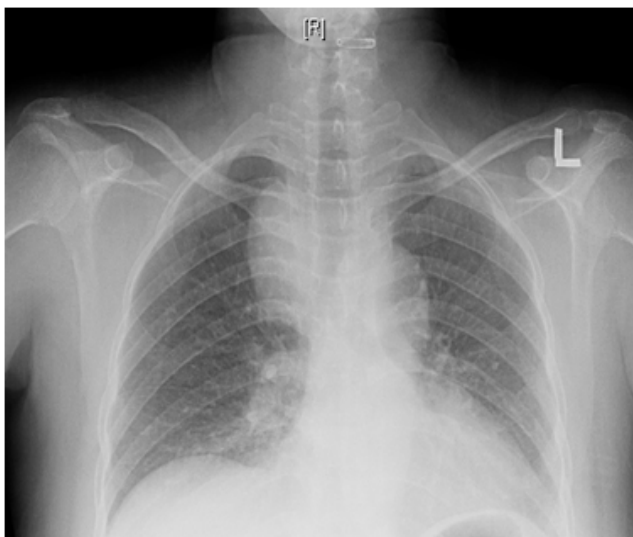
Chest x-ray of Case 1
